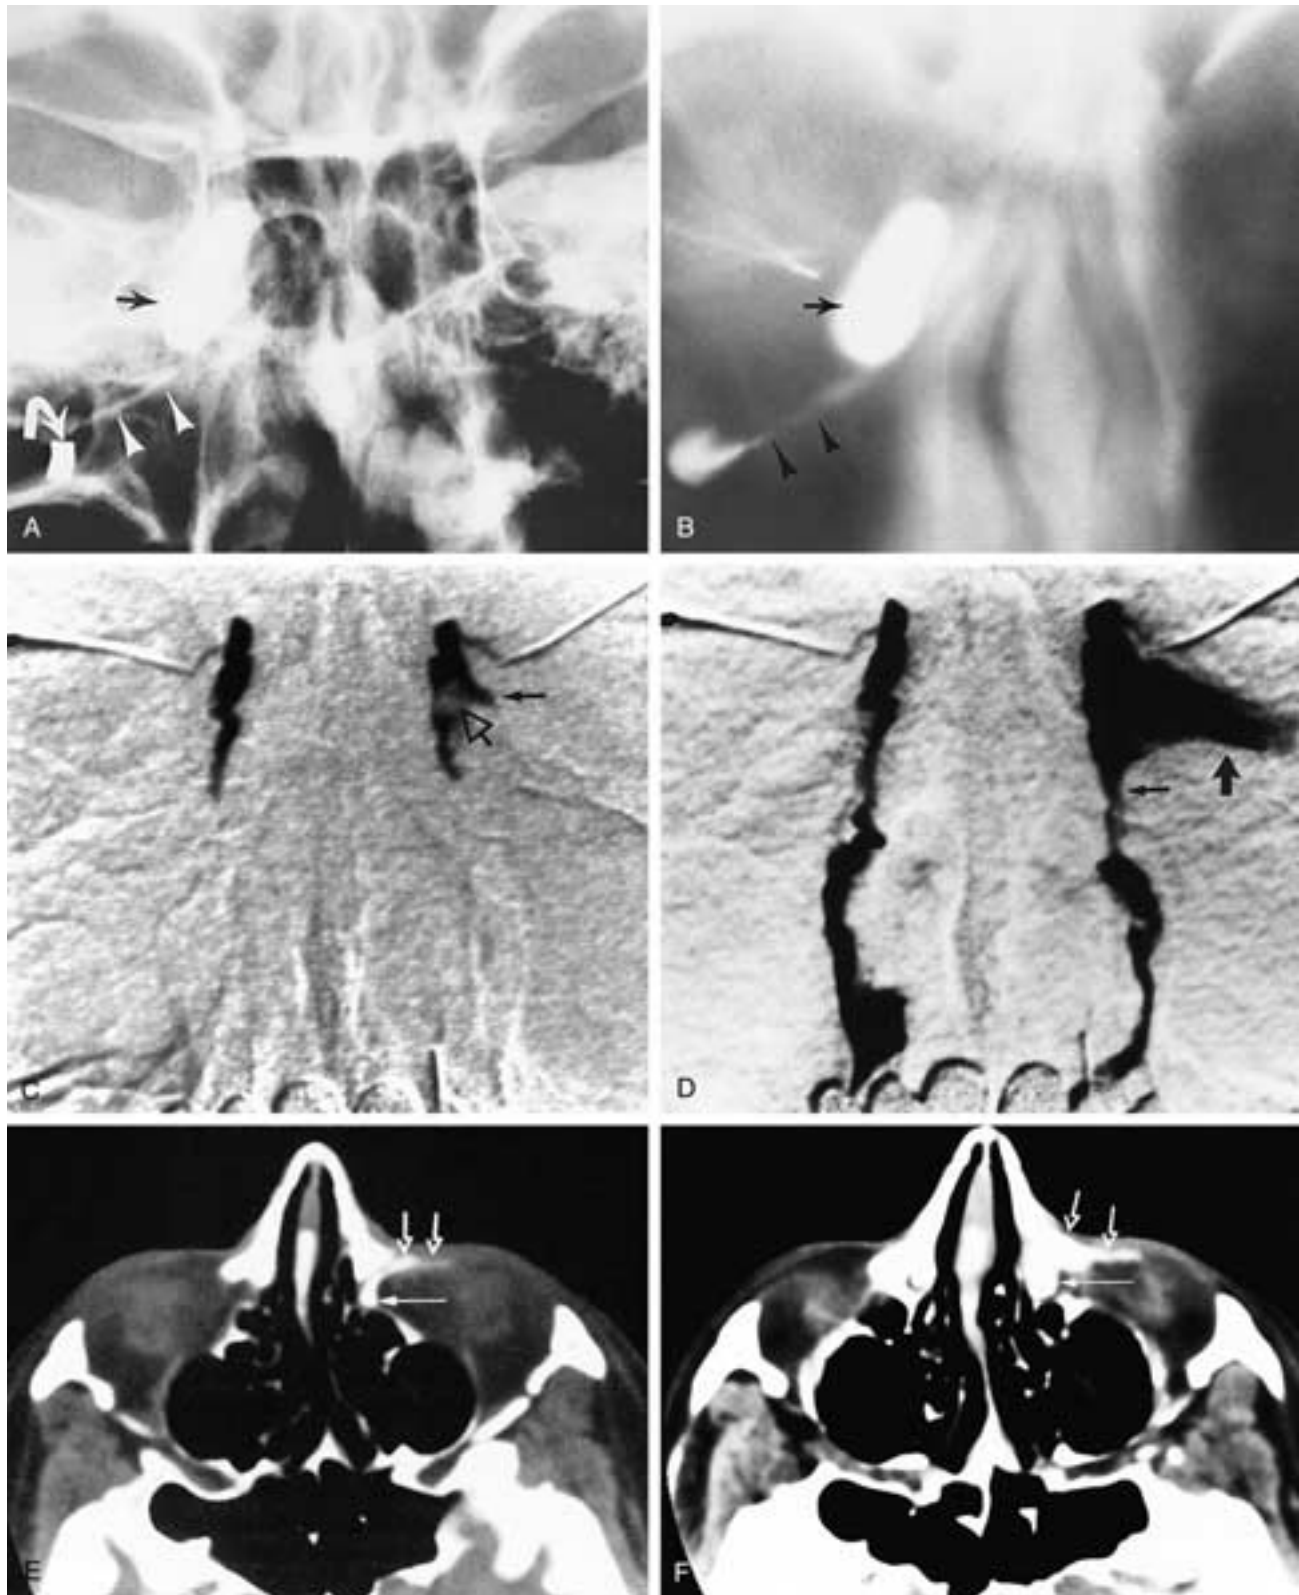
Fistulas and sinus tracts in preseptal tissues. A and B, Patient with epiphora and dacryocutaneous fistula draining below the inferior orbital rim. A, DCG, frontal view. B, Tomographic image. Dilated lacrimal sac (*arrow*). Fistula (*arrowheads*) seen extending from the distal lacrimal sac to the metallic marker on the skin surface at the cutaneous end of the fistula (*curved arrow*). C to F, Patient with a 2-year history of intermittent swelling of the left inferior eyelid causing closure of the eye and epiphora. Sinus tract into the lower lid in a patient with Crohn's disease. C, Early DCG image shows a suspicious ill-defined filling defect (*open arrow*) of the inferior left lacrimal sac, just above the origin of the nasolacrimal duct. Abnormal projection of contrast material in the lateral wall of the left lacrimal sac (*thin arrow*). D, Later DCG image. A large amount of contrast material extends inferolaterally toward the lower lid (*vertical arrow*). Contrast also enters the nasolacrimal duct (*horizontal arrow*) to empty into the nasal cavity. E, Axial CT-DCG shows contrast material extending from the lacrimal sac (*thin arrow*) to enter the soft tissues of the lower lid (*open arrow*). F, More inferior axial image shows the abnormal location of contrast material in the left inner canthus and lower lid (*open arrows*) and an enlarged collection of contrast material in or surrounding the left lacrimal sac (*thin arrow*).
